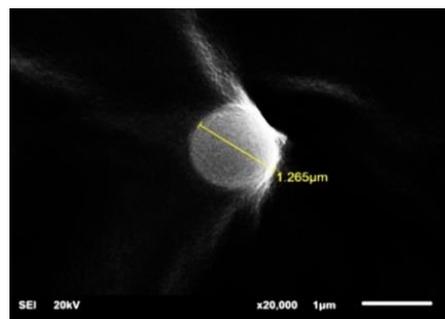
The particle size of niosome encapsulate extract with TEM before reduced by ultrasonic bath
